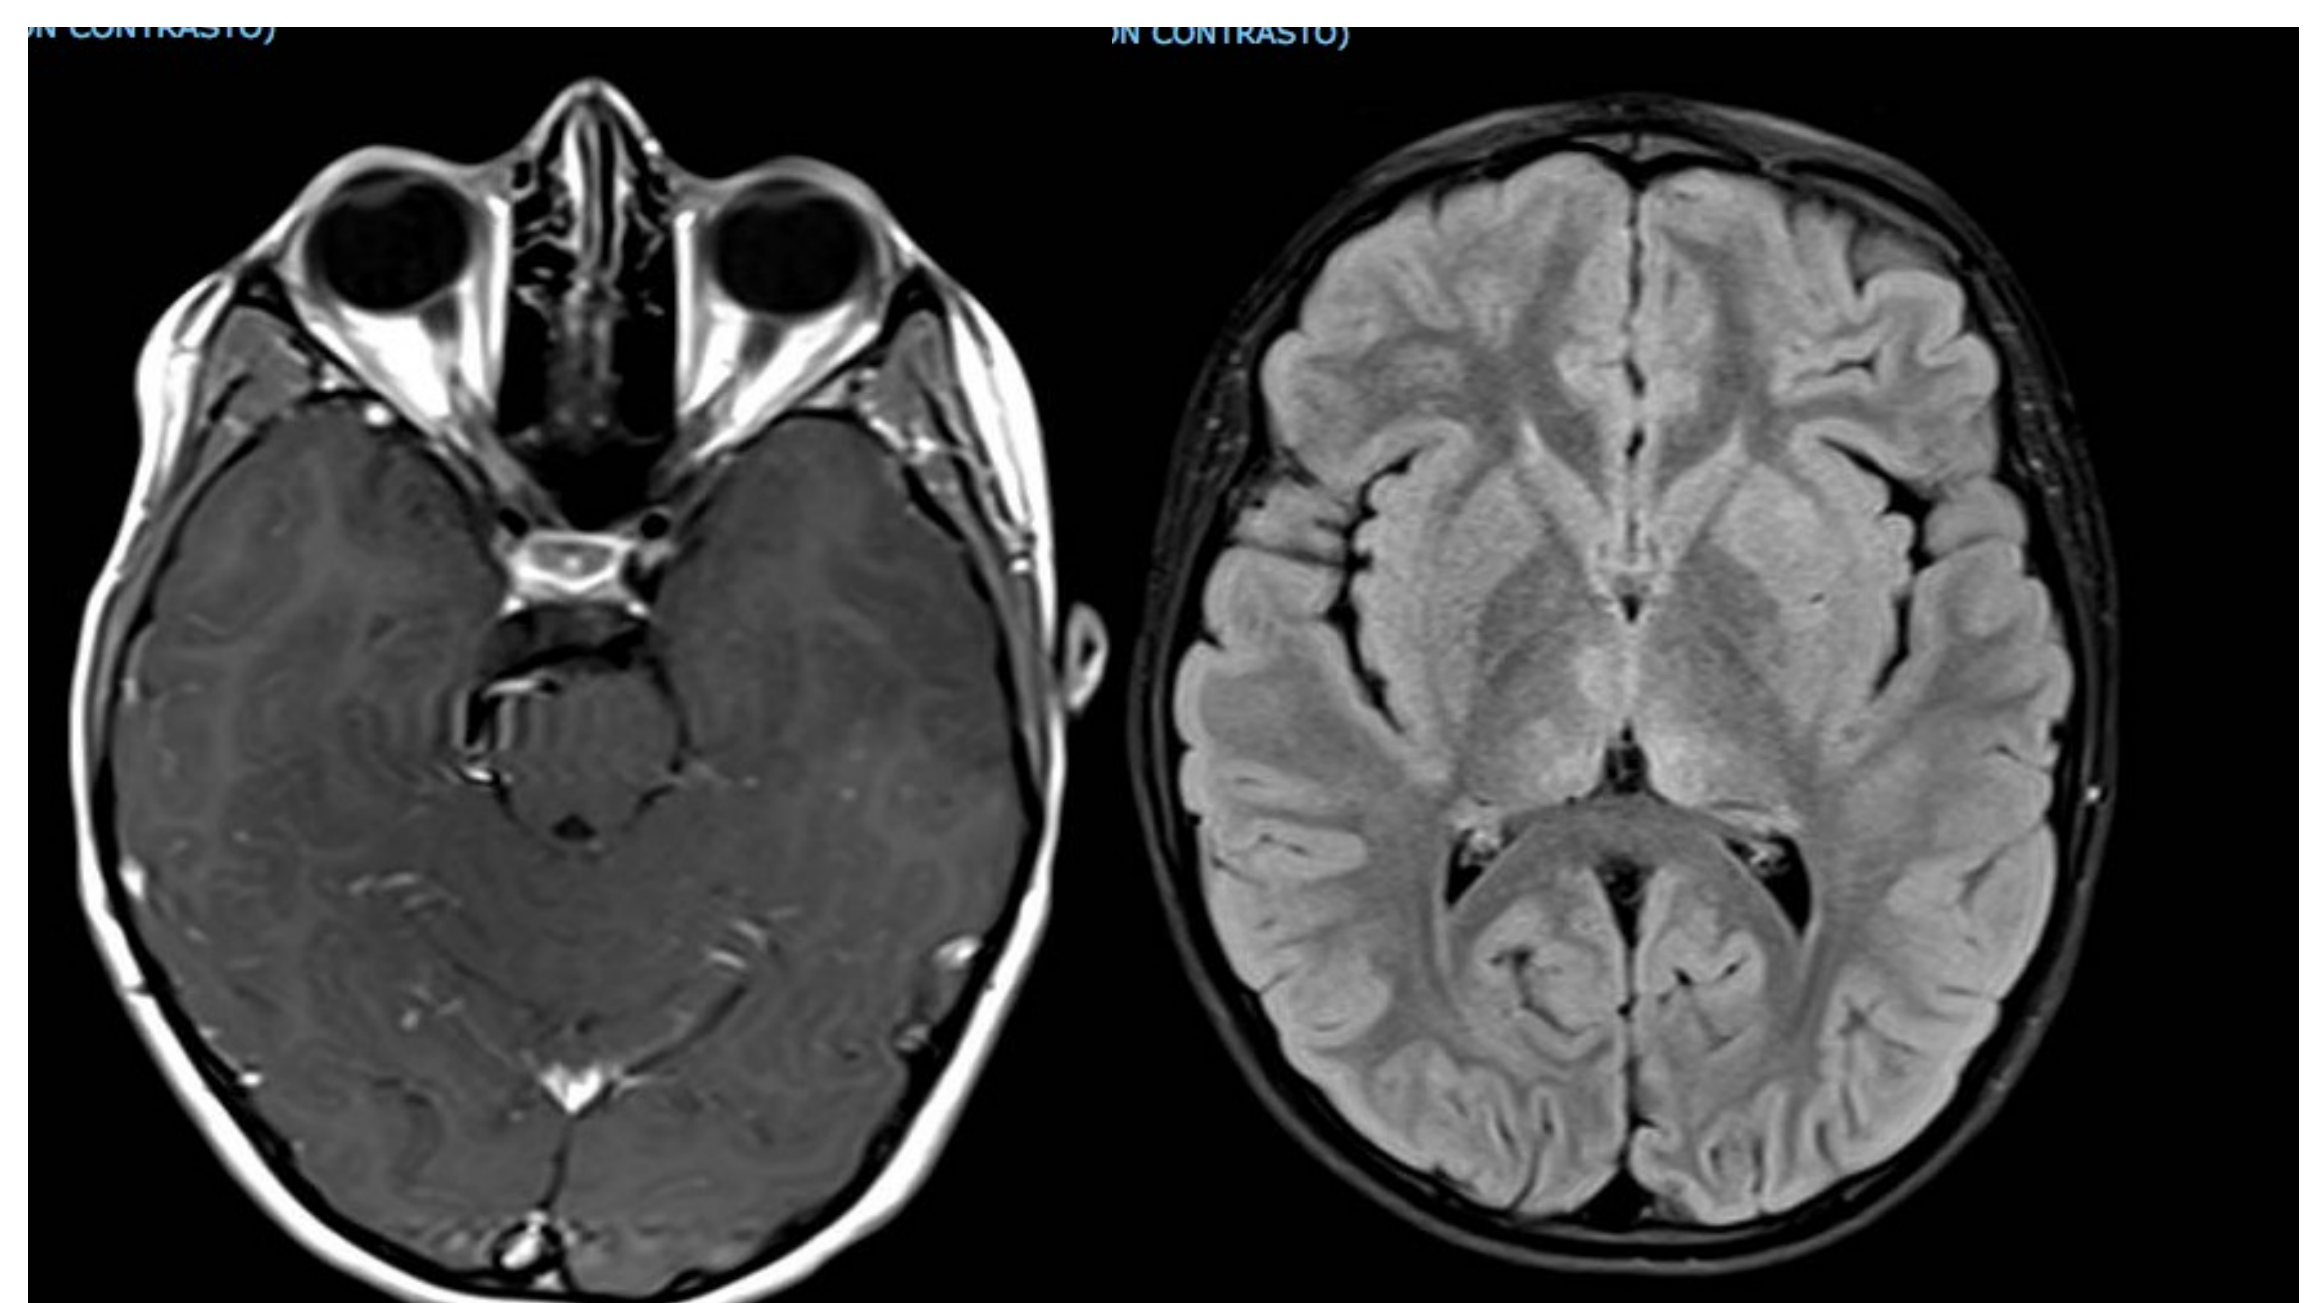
Brain MRI of the 7 years old girl showed optic nerves thickened and tortuous with post-Gd enhancement and T2-Hyperintensive lesions of thalami and basal ganglia.
